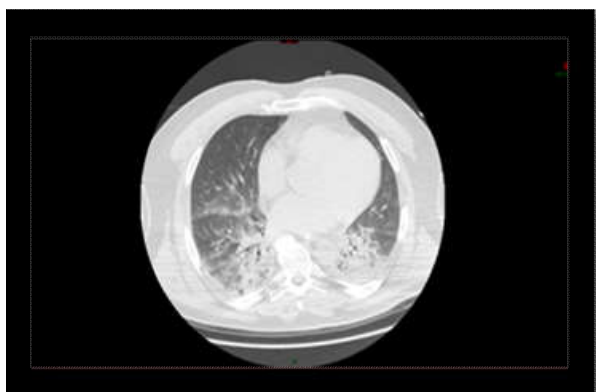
Admission CT scan
